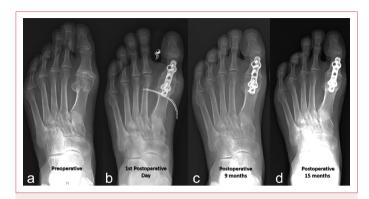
Asymptomatic non-union case in a 57-year-old female patient. (a) Pre-operative radiograph showing the Grade 4 Hallux Rigidus. (b) The radiograph on the 1st post-operative day, demonstrating fixation with a dorsal plate. (c) Nine-month post-operative radiograph showing evidence of delayed healing and non-union signs. (d) Fifteen-month post-operative radiograph confirming persistent non-union. However, the American Orthopaedic Foot and Ankle Society score was 77 points (good), and the Visual Analog Scale was 2 points at the 65th-month final follow-up.
